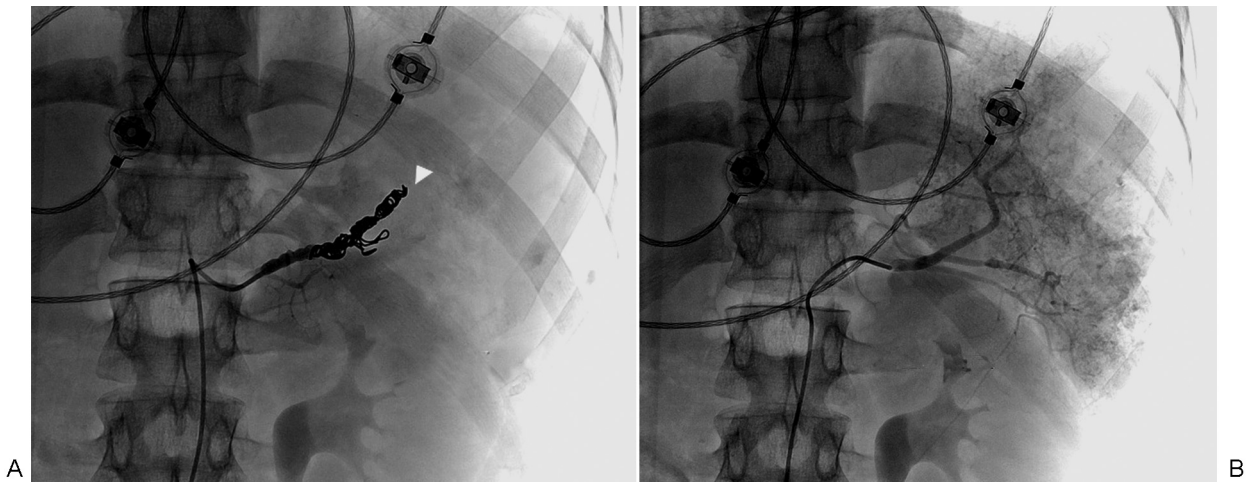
(A) Angiography shows no extravasation. (B) Preemptive embolization of the main splenic artery was performed based on the computed tomography findings.
